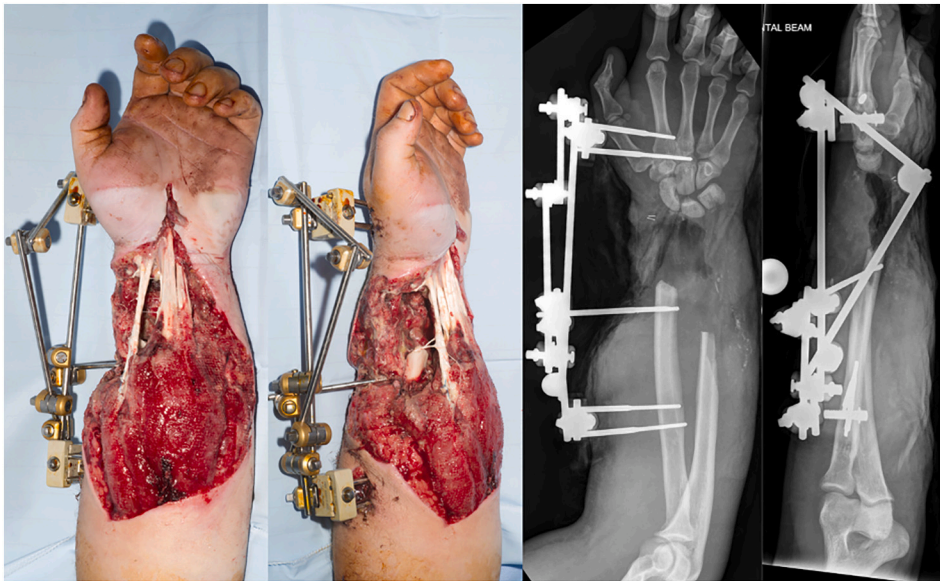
Clinical photographs and x-rays post debridement.
